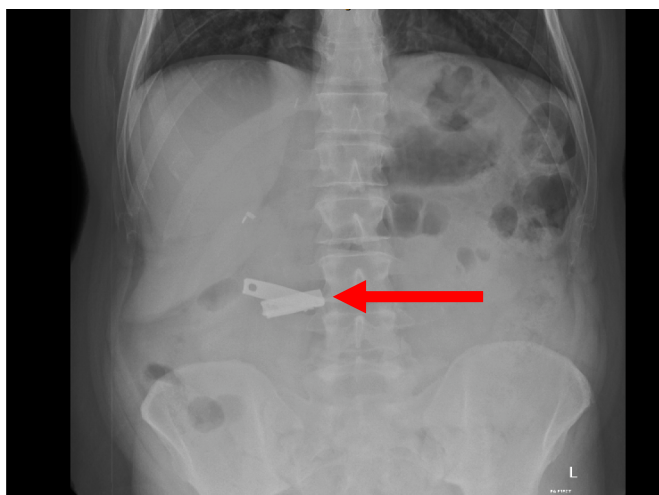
Day of ingestion abdominal X-ray (AXR): Nail clippers seen in D2/D3 of duodenum (red arrow).
